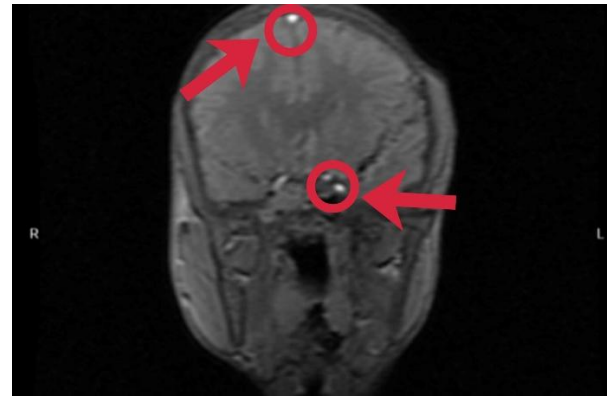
R indicates the right side of the patient's head (left side of the image). L indicates to the left side of the patient's head (right side of the image) in the brain MRI FLAIR.
